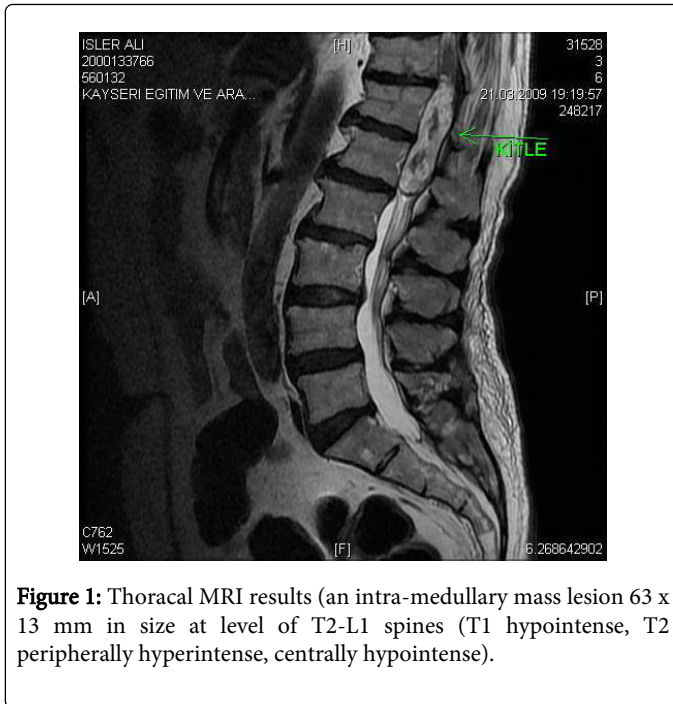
Thoracal MRI results (an intra-medullary mass lesion 63 x 13 mm in size at level of T2-L1 spines (T1 hypointense, T2 peripherally hyperintense, centrally hypointense).
